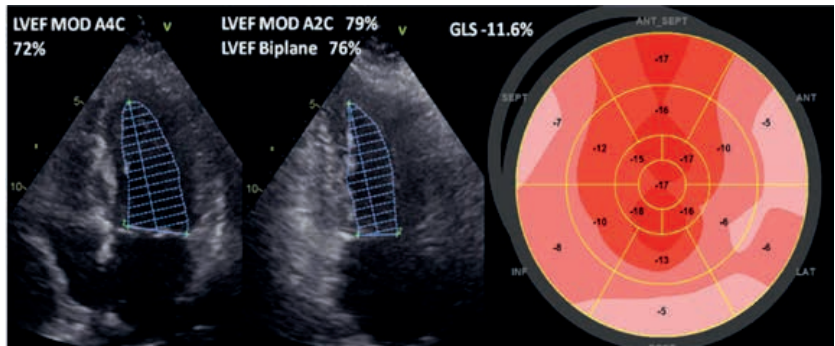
In an asymptomatic patient with severe aortic stenosis and preserved left ventricular ejection fraction (LVEF 76%), the global longitudinal strain GLS evaluated by speckle tracking echocardiography is impaired -11.6%, and worse in the basal segments of the left ventricular myocardium, indicating endomyocardial dysfunction.
